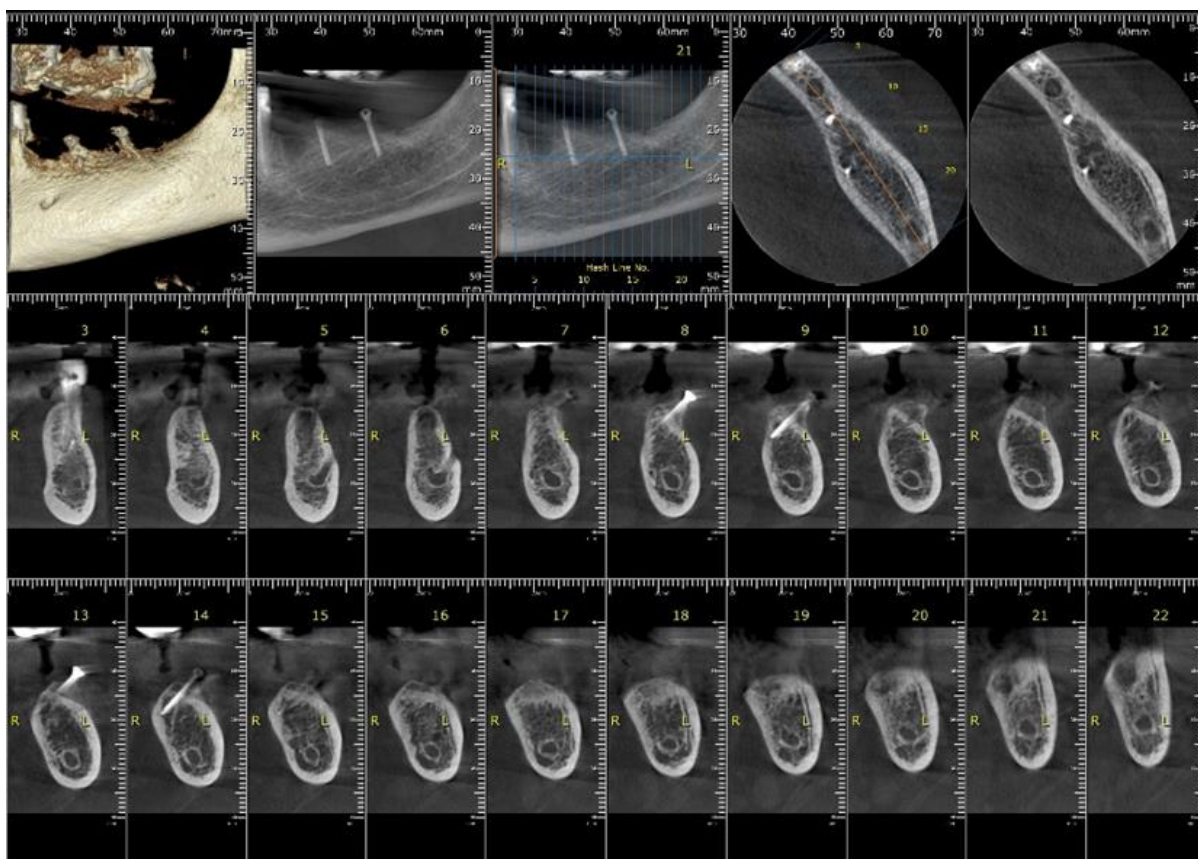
CBCT after 5 months postoperatively
